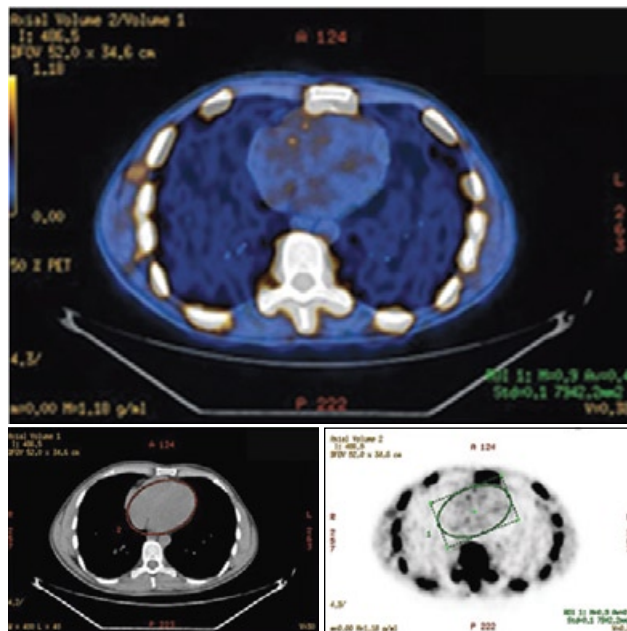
This figure demonstrates a typical region of interest (ROI) that was assigned to the cardiac silhouette on each slices of CT and the corresponding PET slice. As noted above, the degree of ¹⁸F-NaF uptake is quite non-uniform throughout the selected slice and thus, is of limited value for accurate assessment of related calcification. Also, please note that the process of uptake is diffused and does not conform to the shape of the ventricles lumen in either ventricles. In this particular slice the volume of the selected ROI was 30.8 cc, and the SUVmean on the corresponding PET slice was 0.5. Therefore, the molecular calcification score for this particular slice was calculated to be 15.4 (30.8x0.5 = 15.4). The Global Calcification Score for the entire heart was calculated by adding the individual slice values generated by this approach.
